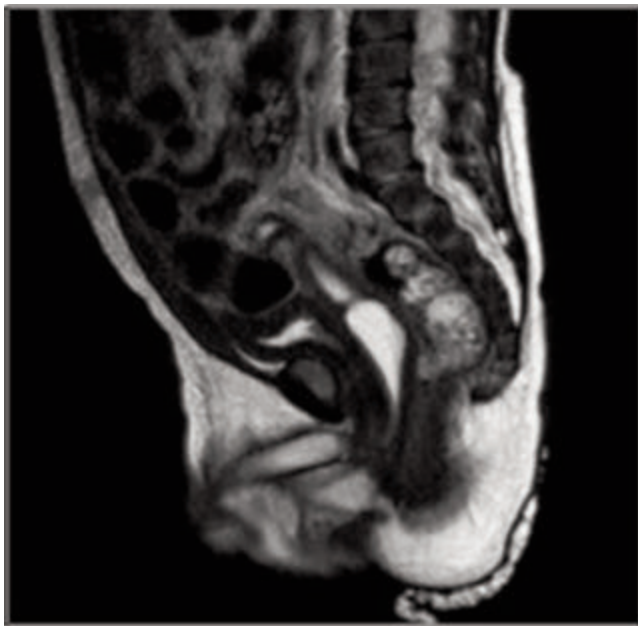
Sagittal image of pre-operative magnetic resonance imaging.
